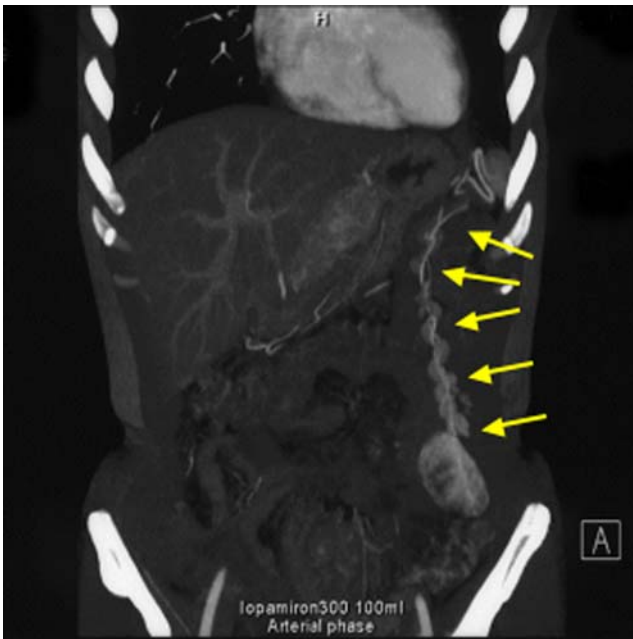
Enhanced computed tomography exhibited a well-defined heterogeneous tumor with contrast enhancement in the left lower quadrant of the abdomen, and demonstrated that the left gastroepiploic artery (arrow) was feeding the tumor.
